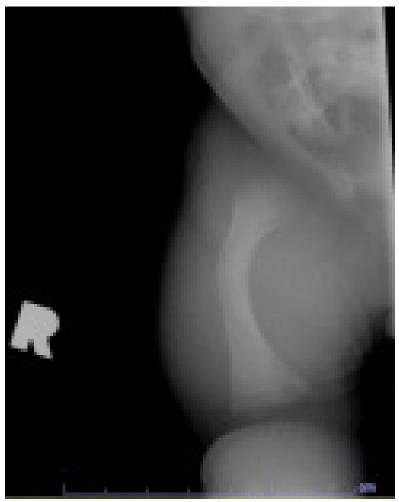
Right thigh xray on DOL 14 showing bowing and sclerosis of the femur with faint linear lucency extending through the posterior cortex of the mid femoral shaft
